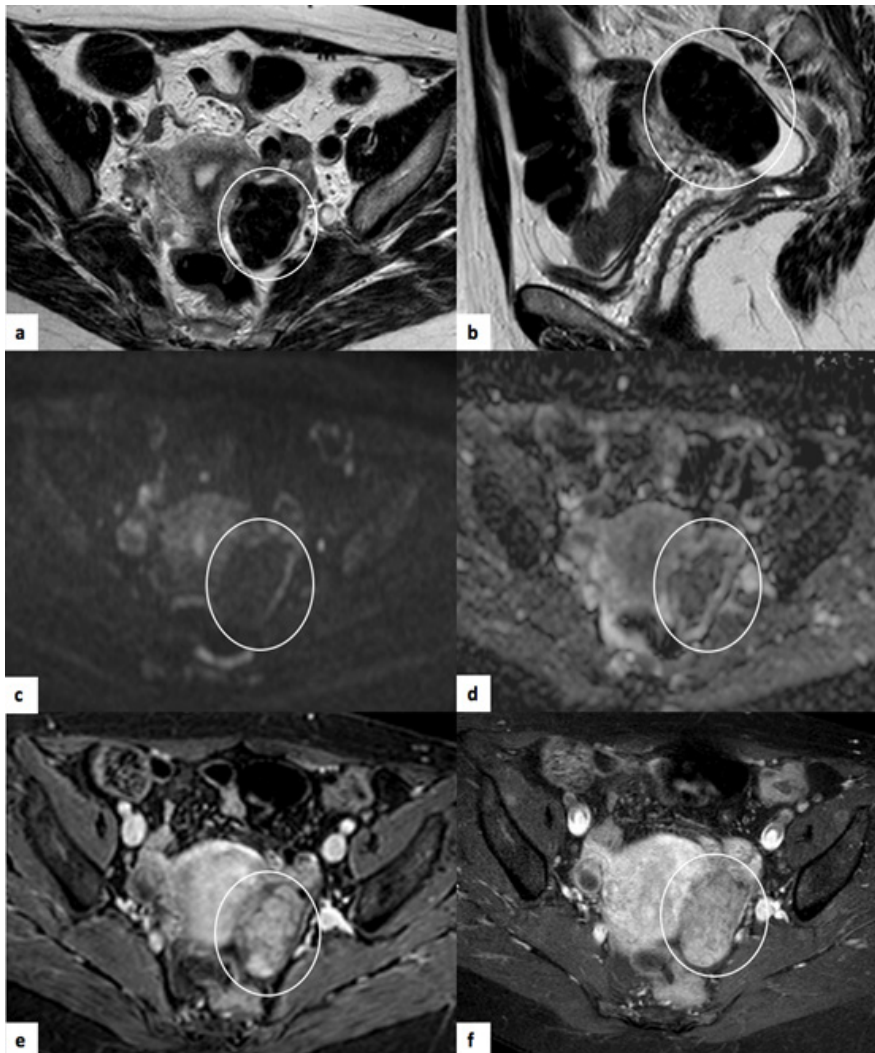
Primary leiomyoma of the left ovary. Pelvic MRI of 52-year-old woman. (a) Axial T2-weighted image: the left ovarian lesion (circle) is markedly hypointense on T2WI (signal similar to muscle tissue). (b) Sagittal T2-weighted image where it is possible to appreciate the same characteristics. (c) and (d) correspond to DWI ($b=1000$) and ADC map, respectively, where it is shown that this lesion does not present restricted diffusion. (e) T1WI with fat saturation after intravenous contrast-enhancement - T1 SPAIR (dynamic study) and (f) delayed phase after intravenous contrast - T1 SPIR, where it is possible to appreciate the enhancement of the lesion, which is not superior to that of the myometrium.
